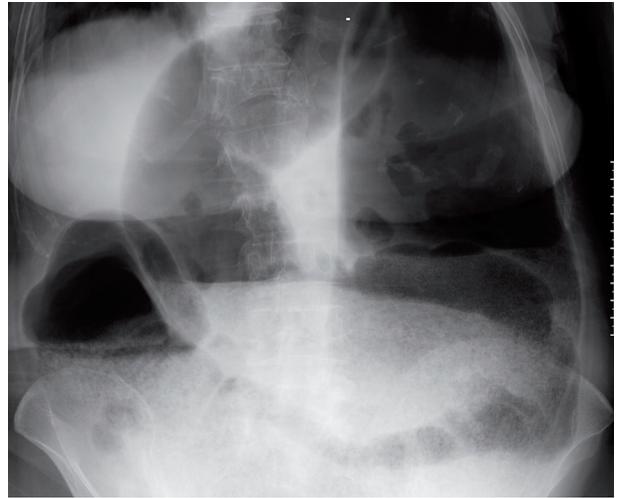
The abdominal x-ray image before the procedure
